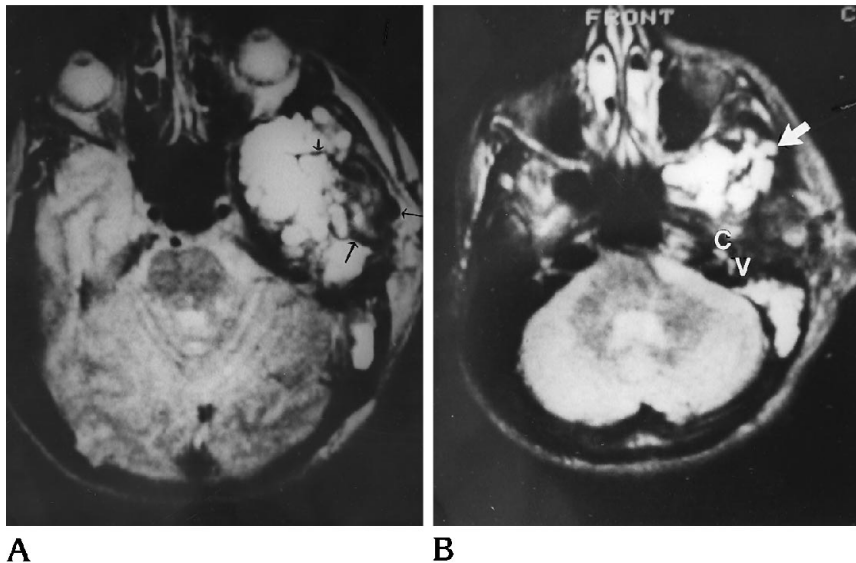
T2-weighted (2500/90/1) axial spin-echo MR images.
